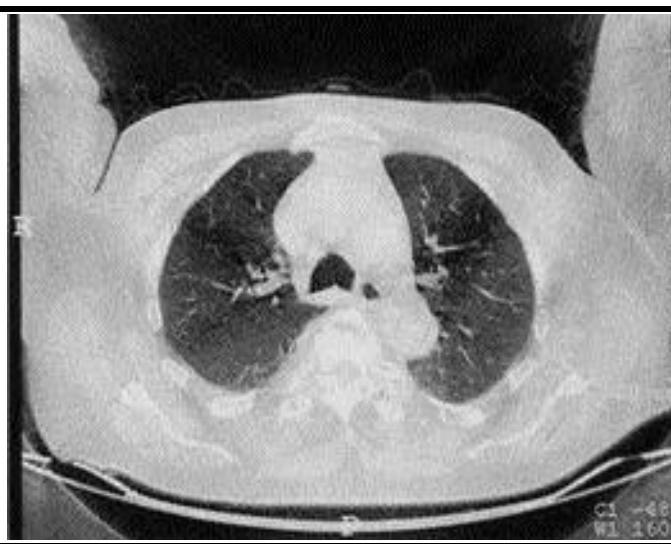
Ground glass appearance on HRCT.
